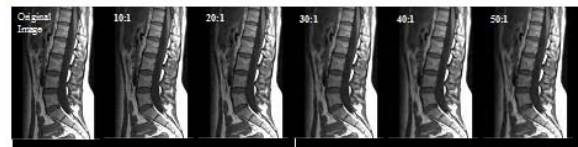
Comparison between original and compressed MRI Spine images
